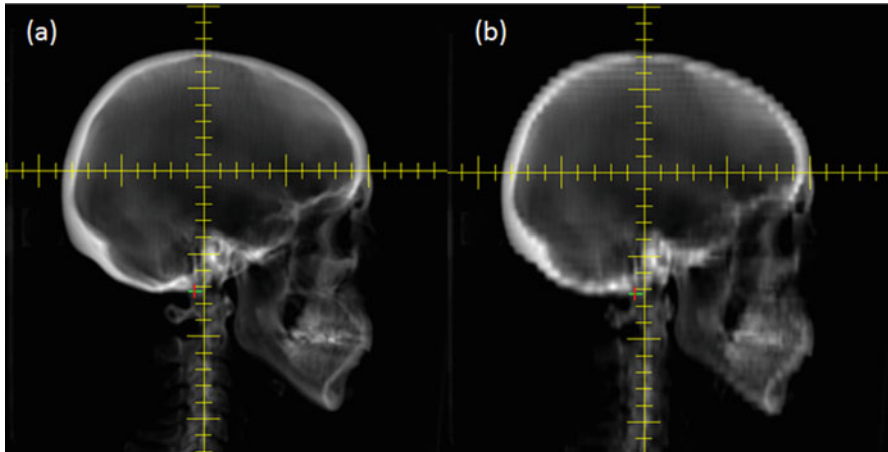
Digital reconstructed radiograph (DRR) generated from (a) CT with 1.5 mm slice thickness showing better visualization of anatomical details than (b) the DRR generated from CT with 5 mm slice thickness
